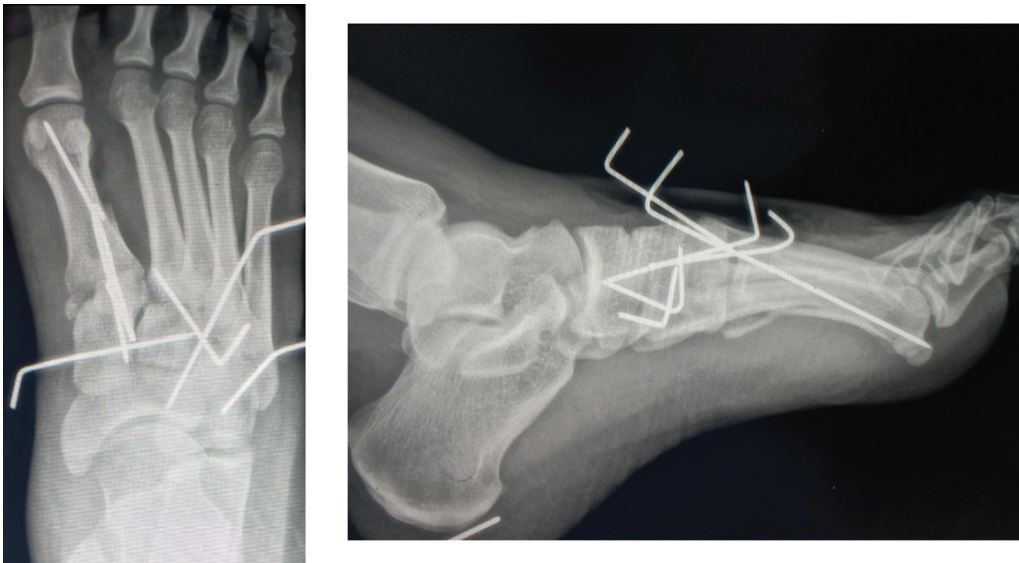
Anteroposterior and lateral foot radiographs after open reduction and internal fixation with Kirschner wires.
